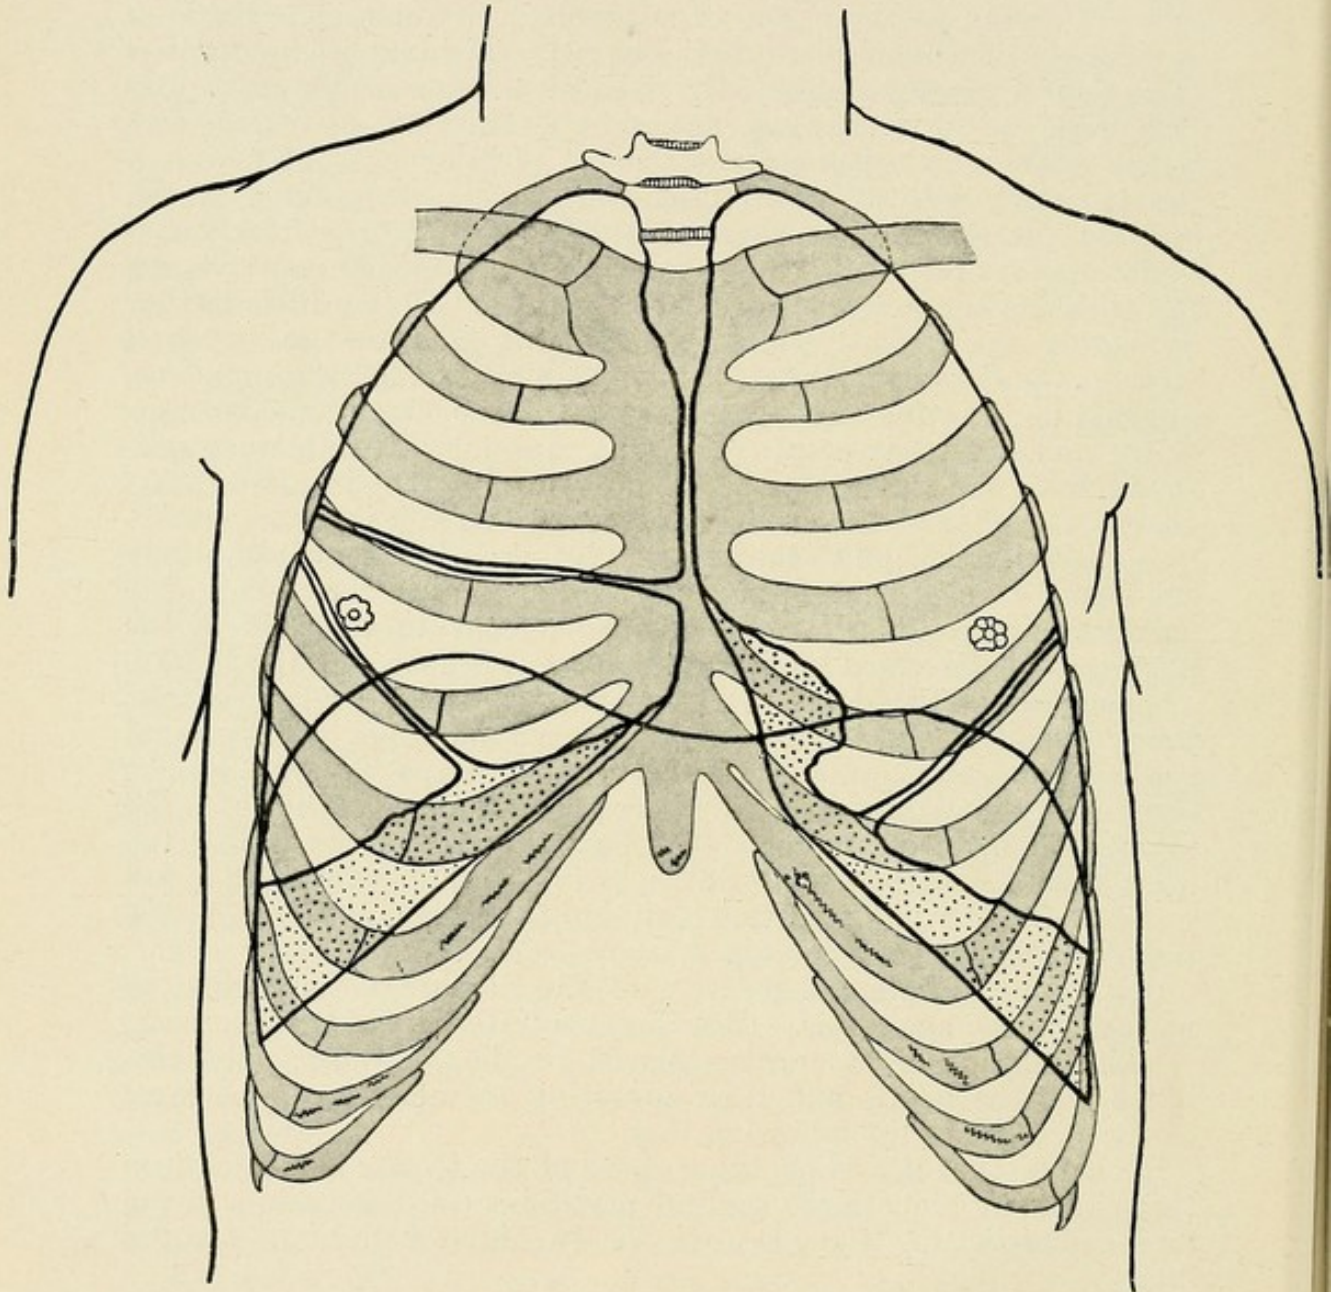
Front boundaries of the lobes of the lung and the pleura. Complementary spaces dotted. Position of diaphragm drawn in accordance with an X-ray picture.
